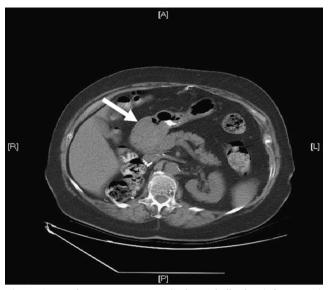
Non-intravenous contrast CT image indicating (*white arrow*) large soft tissue structure at level of the gastric antrum and duodenal bulb (note prior right nephrectomy with absence of the right kidney).
